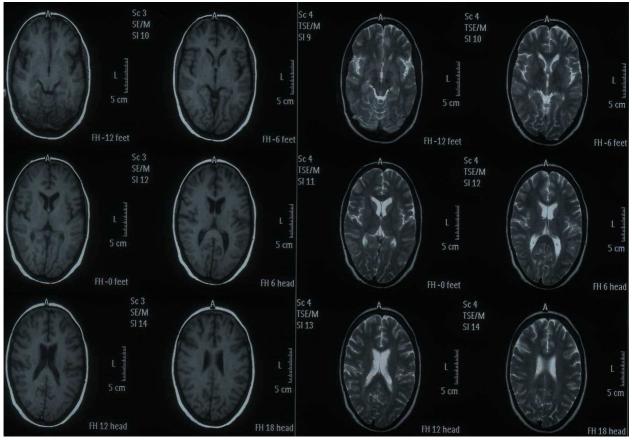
MRI Brain - Normal Study
